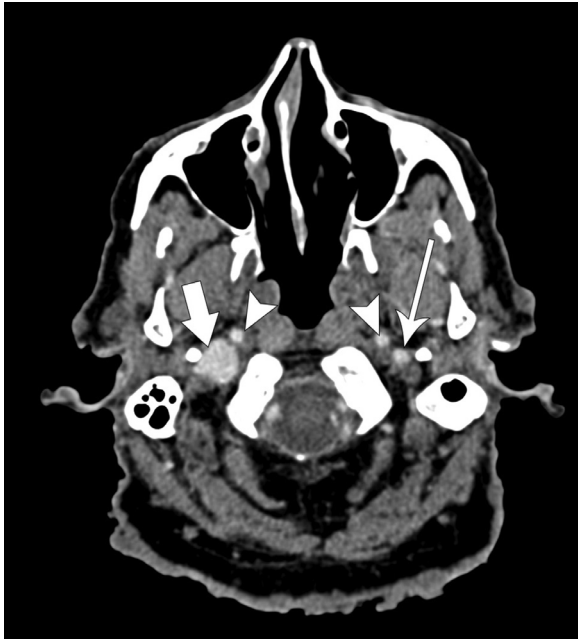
Axial contrast enhanced CT neck at the level of the skull base showing ectatic right internal jugular vein (arrow) compared to the normal caliber left internal jugular vein (long arrow). Both internal carotid arteries are also normal in size (arrowheads).
